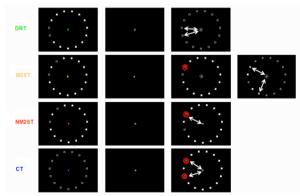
The figure shows the 4 tasks used in this study (up to down: DRT, M2ST, NM2ST, CT; left to right: cue, delay and response period). In the cue period all tasks highlight two targets, except for the CT. During the response period subjects were required to make movements according to the individual task rules. These movements are indicated by the arrows. The red circles indicate goals presented in the response period that are not present in the cue period. Please note that the response period in the M2ST is comprised of two parts, first a goal comparison, followed by an answer screen.
